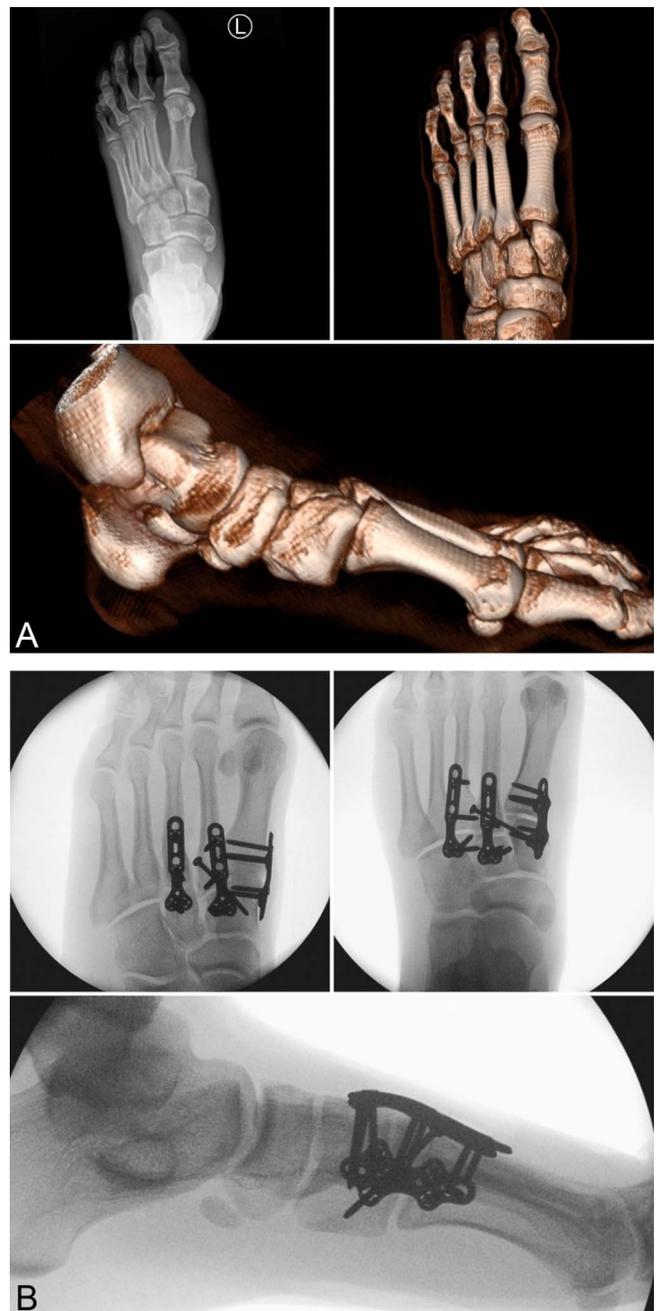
A, Preoperative plain radiographs and computerized tomography with 3D reconstruction of an unstable Lisfranc complex injury from our series. B, Fixation with DBPs of and a retrograde Lisfranc screw.
